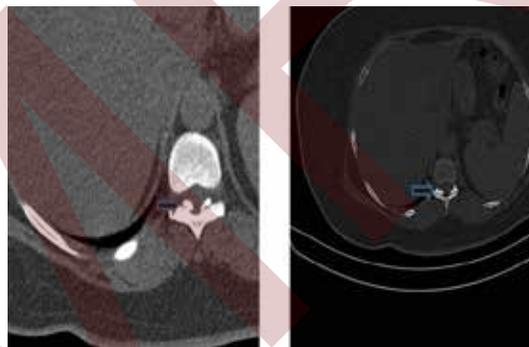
CT scan of thoracic spine showing ossified ligamentum flavum (arrow)
